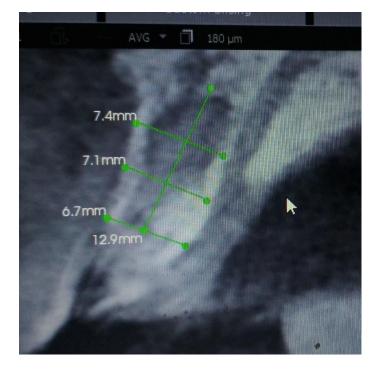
CBCT (PREOPERATIVE)
